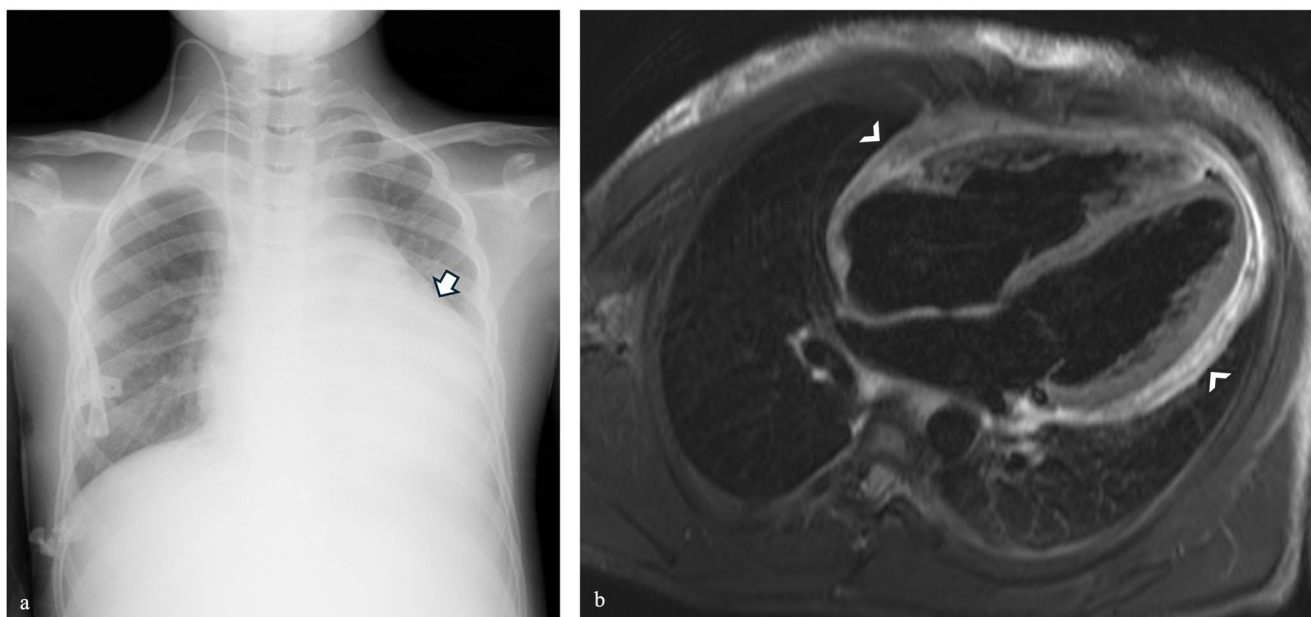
In a, chest X-ray of a nine-year-old girl under treatment with idarubicin for acute myelogenous leukemia who showed dyspnea and desaturation. The radiograph indirectly shows a pericardial effusion with a widened cardiac silhouette and flattening of the cardiac waist
